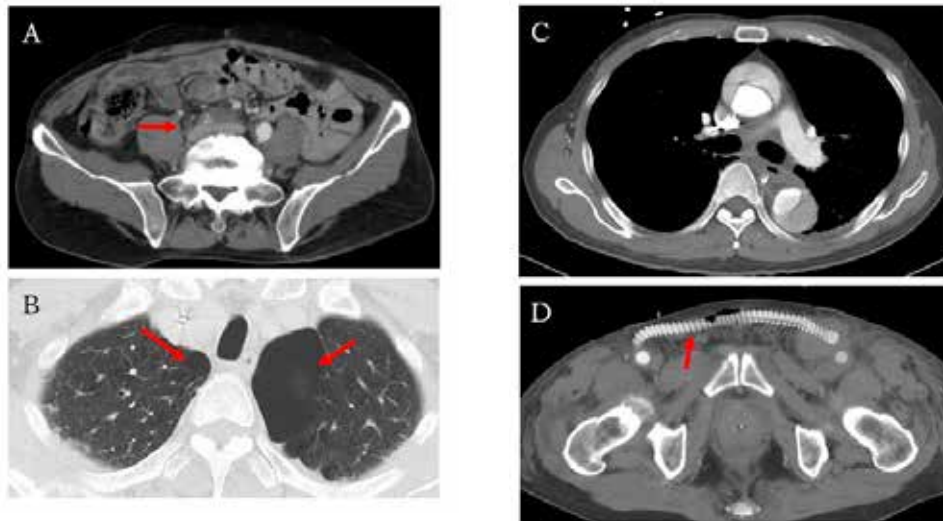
Preoperative computed tomography. (A) Right common iliac artery is occluded (red arrow). (B) Bilateral bullae are seen (red arrow). Preoperative retrograde acute type A aortic dissection was documented upon computed tomography. (C) A new dissection is seen in the ascending aorta. (D) The femoro-femoral bypass is intact (red arrow).
